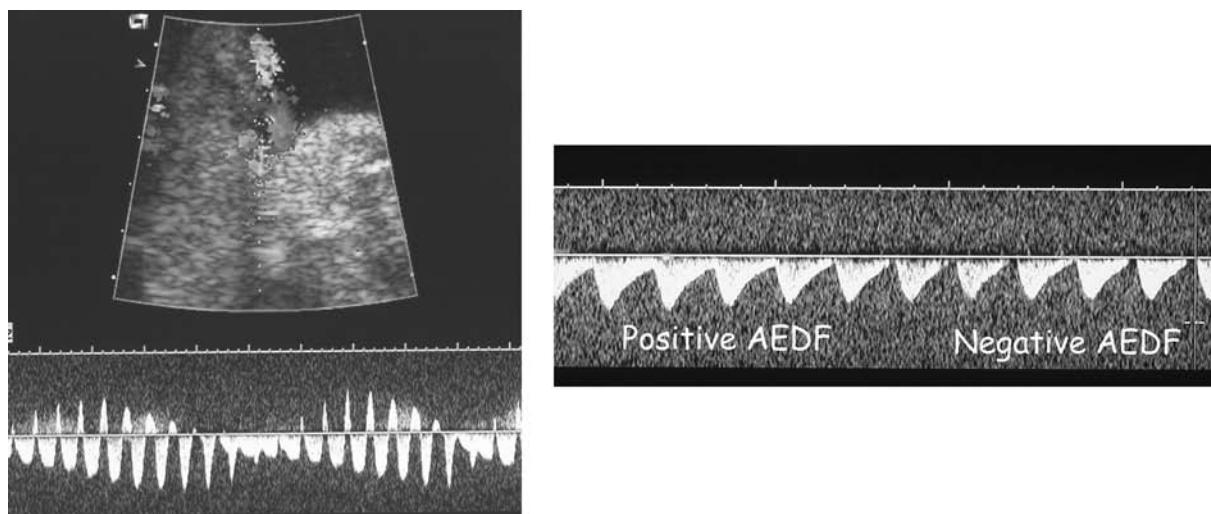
iA/REDF: Abnormal Doppler findings in umbilical artery with intermittently a positive, and negative flow (right) and reversed flow (left), a sign of retrograde transmission of an AA wave from in the umbilical artery.
